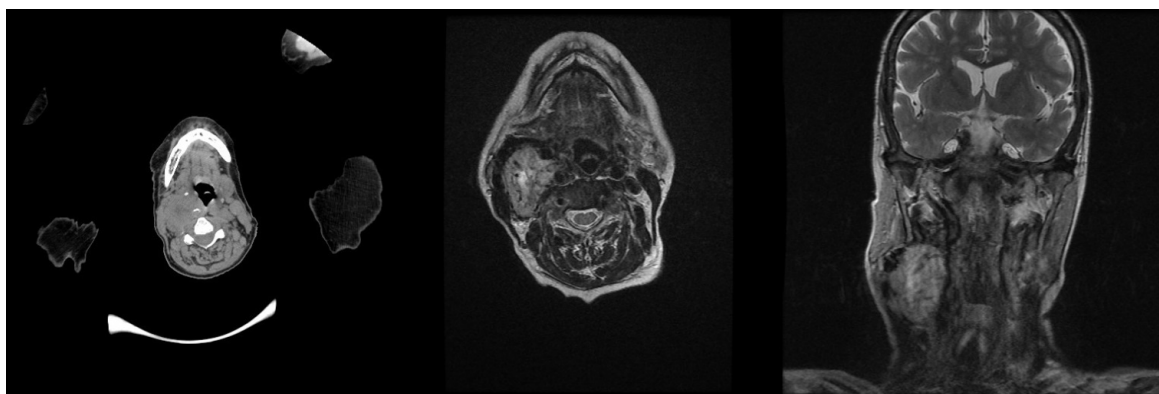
Computed tomography (CT) scan and Magnetic resonance imaging (MRI) showed hyper vascularized tumor mass on the right carotid bifurcation
